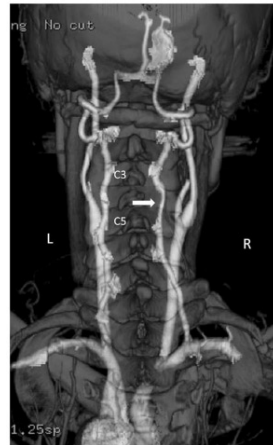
3D reformat CTA viewed from posterior demonstrates narrowing of the V₂ segment of the right vertebral artery (arrow) extending from C5 to C3, with normal caliber vessel both cranially and caudally.
